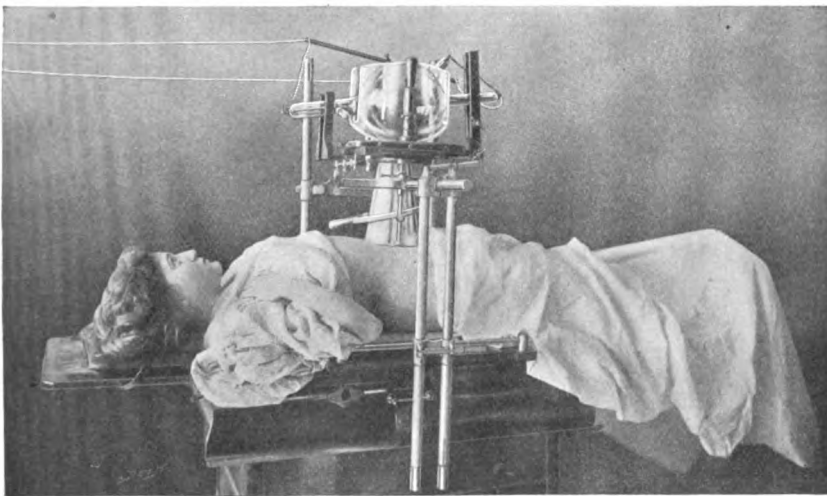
Renal radiography with a compression cylinder. The knees should be drawn up and a pillow placed under the shoulders as in Fig. 677.
